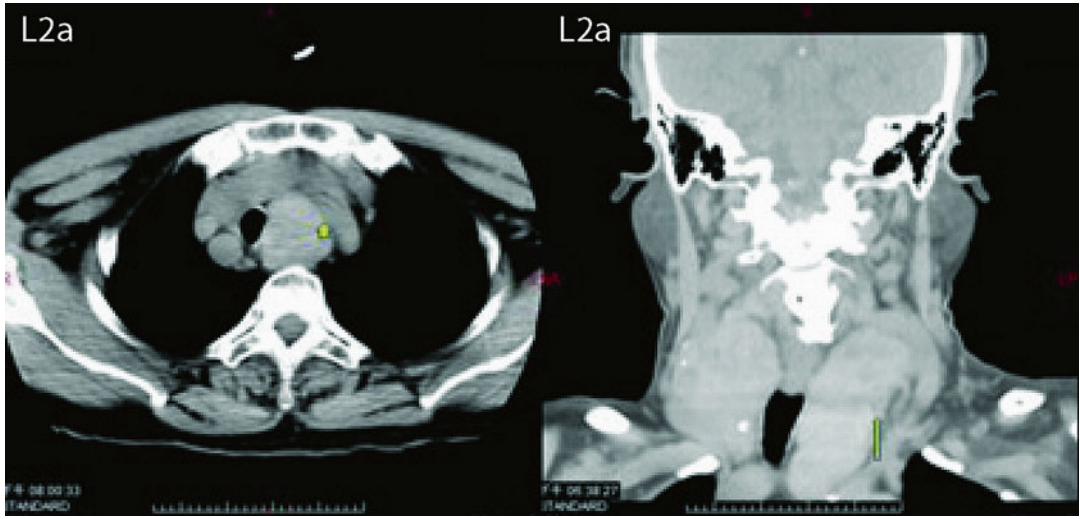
(continued) (c) CT Scan images showing *L2a* Abnormal acquired-lateral
